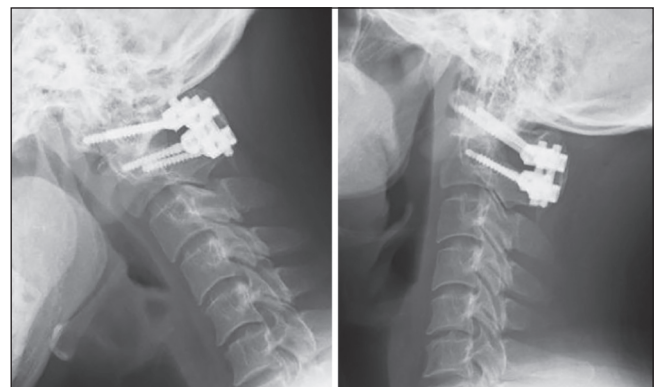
Post-operative flexion/extension lateral radiographs of cervical spine showing rigid fixation between atlas and axis
